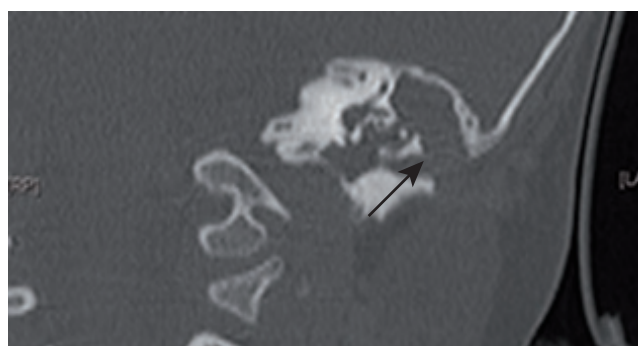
Coronal CT scan in an 8-year-old child. Extensive cholesteatoma filling the left mastoid and middle ear, with erosion of the external ear canal (arrow).
